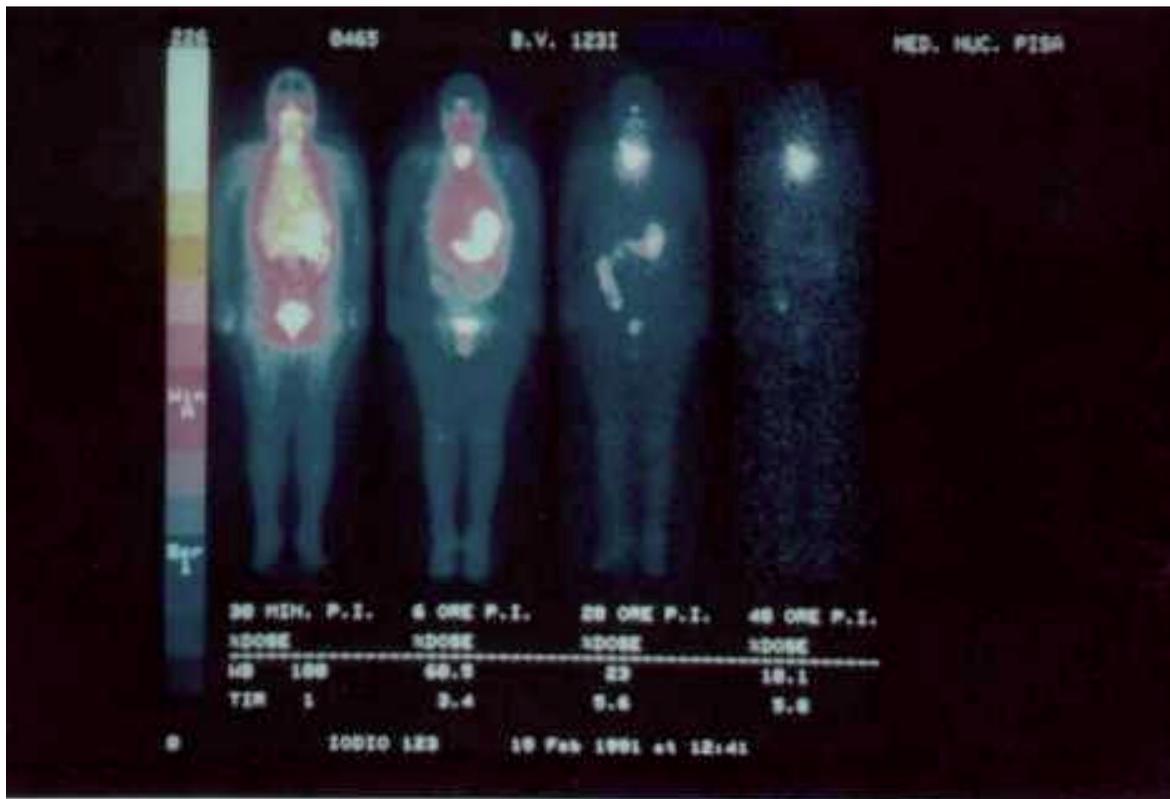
whole body radioiodine scintigraphy.
